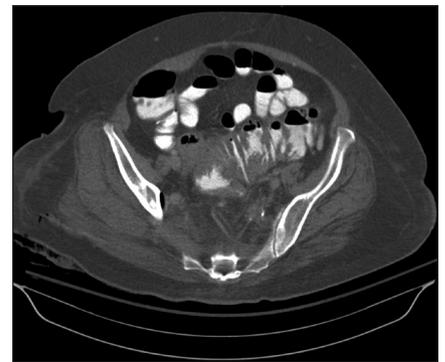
Computed tomography scan of the abdomen revealing a small abscess in the region of the sigmoid colon, with thickening of the bowel wall (center) and inflammation in the right gluteal musculature.
